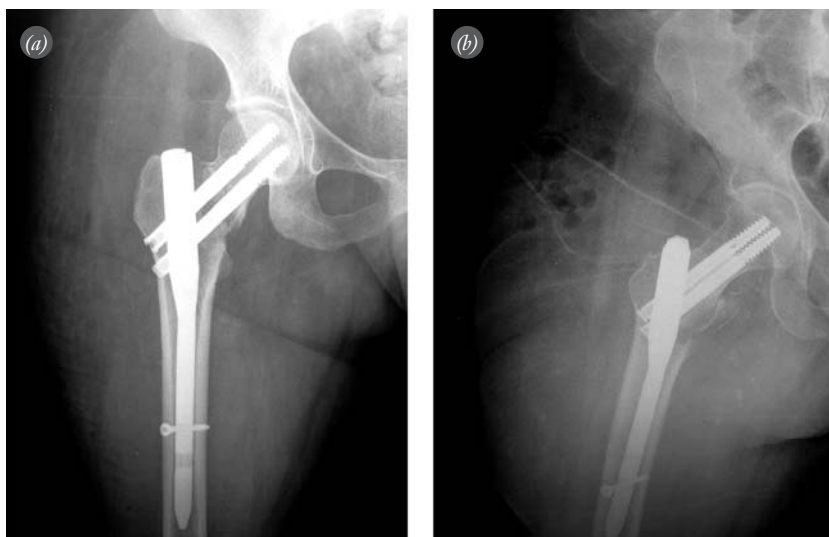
Postoperative (a) anteroposterior and (b) lateral radiographs of the same patient.
